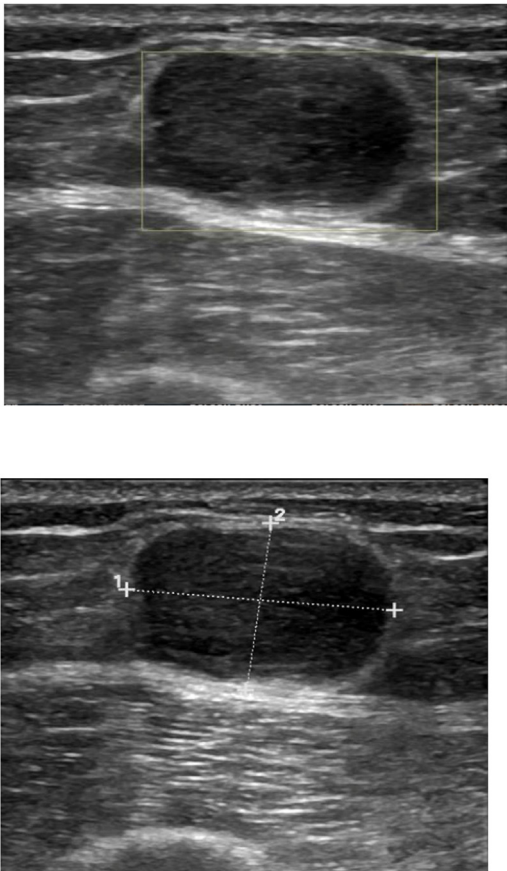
Ultrasound (US) of the left lateral thigh showing a well-demarcated hypoechoic spherical cystic lesion, suggestive of epidermal inclusion cyst B 1: 2.5 cm, 2: 2 cm.
